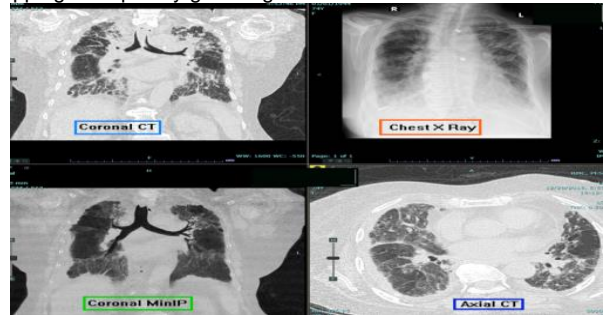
Comparison of axial and coronal HRCT images showing interstitial lung disease with UIP pattern. The basal gradient of UIP is well appreciated on coronal images.
